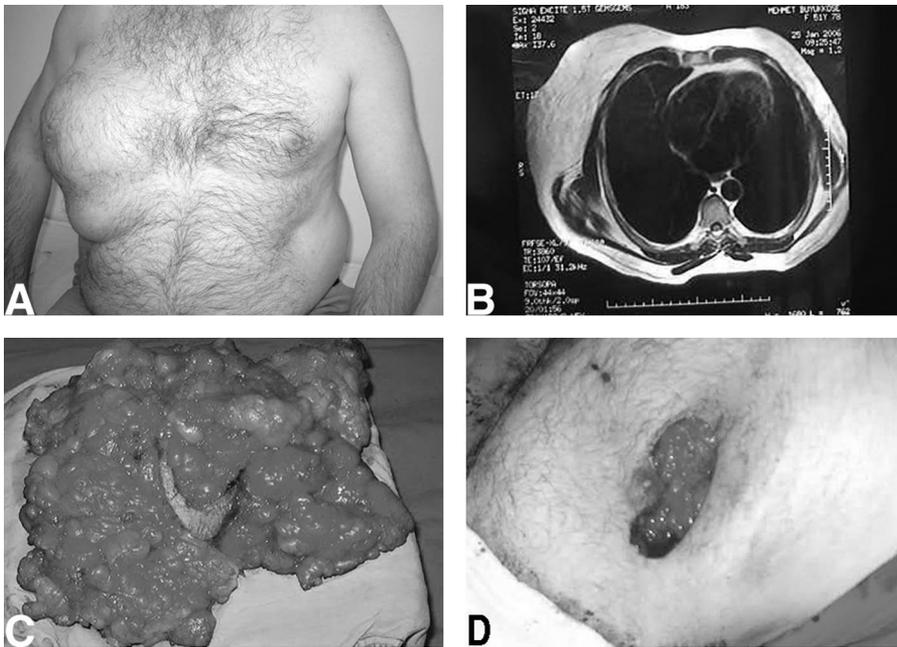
A, Case 1. B, Axial T1-weighted MR image of case 1. C, Typical nonencapsulated lipoma surgically excised with overlying crescent skin. D, After the central excision of the lipoma, minimal fat tissue over the pectoral fascia was left at the base of the surgical area.
